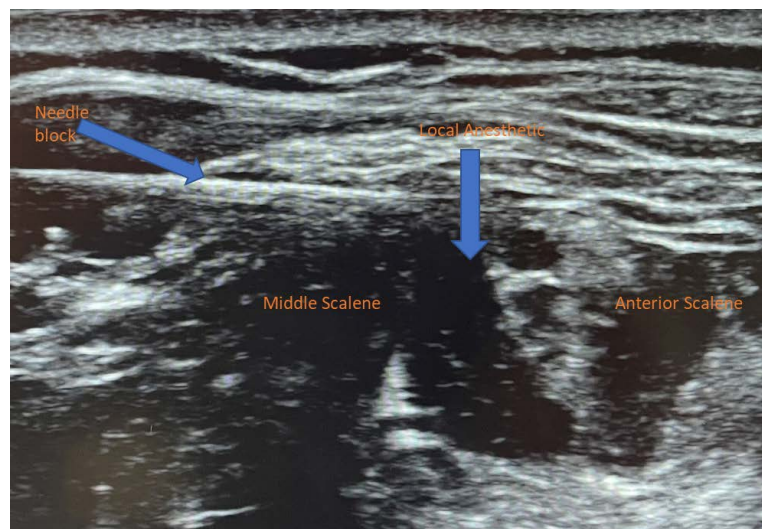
Ultrasound showing the needle and the local anesthetic spread in the interscalene groove (between middle and anterior scalene muscles) along the brachial plexus.
